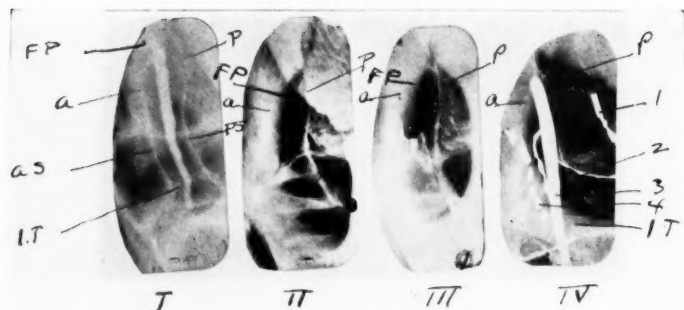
No. I. Injected normal lacrimal sac and duct. No. II, III and IV are x-rays of lacrimal fossa and duct in skull.
